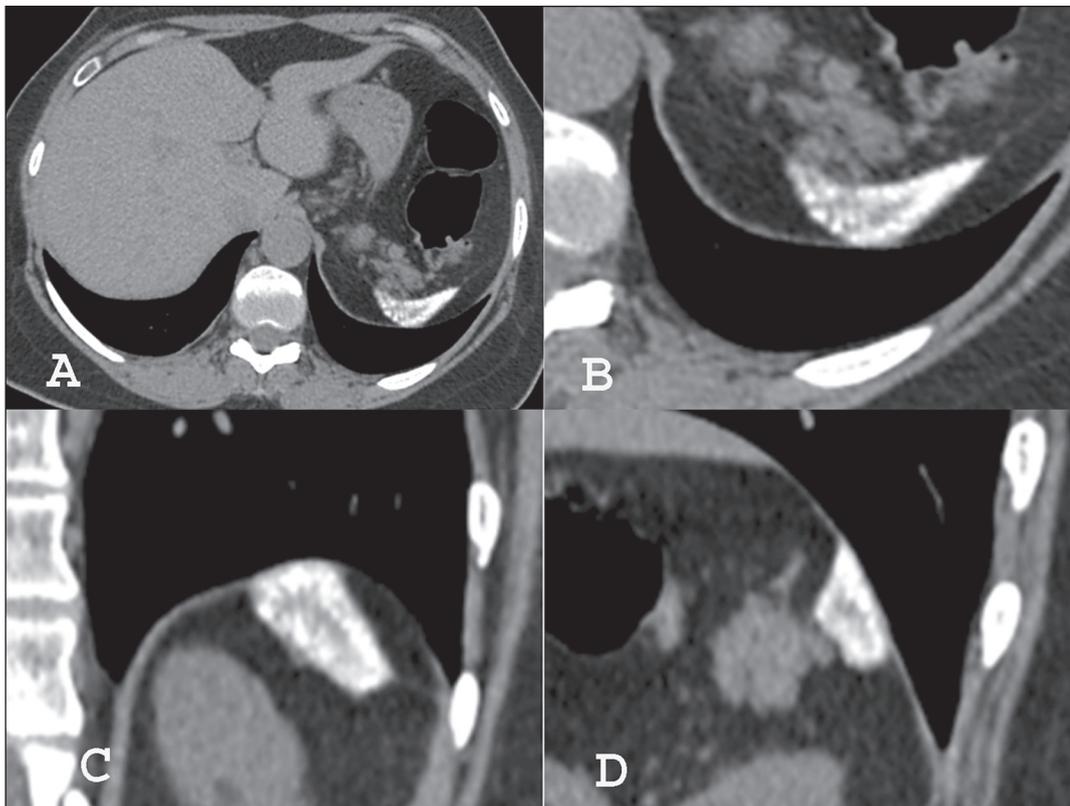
Computed tomography of the chest with mediastinal window settings (A) showing a decreased spleen size, accompanied by diffuse, small, predominantly subcapsular and peripheral, nodular calcifications, some of them confluent, with relative sparing of the central regions. Detail of the splenic region: axial computed tomography scan (B), with coronal and sagittal reconstructions (C and D, respectively), showing the characteristics of the splenic calcifications in more detail.
